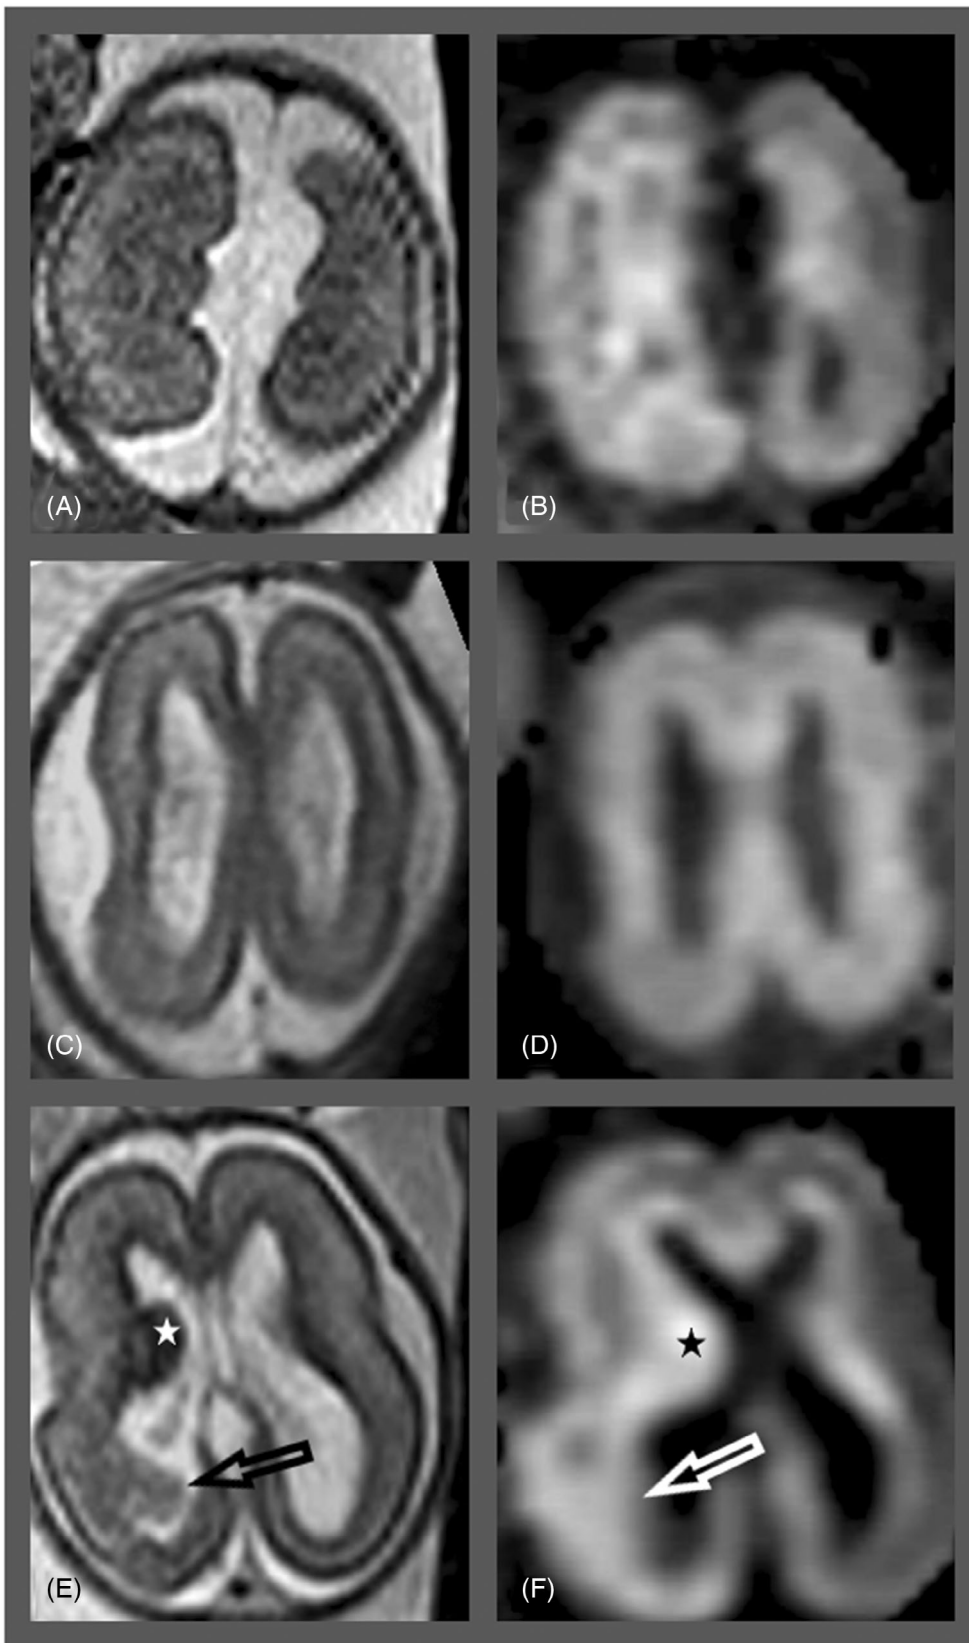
Cortical malformations and loss of cerebral mantle layering. (A, B) in this 21 GW fetus with abnormal medial sulcation (A), DWI shows global loss of layering (B). (C, D) Another 21 GW fetus with abnormal shape of the Sylvian fissures (C) and loss of layering on DWI (D). (E, F) Focal nodular area (arrow, E), probably representing subcortical heterotopia, with corresponding loss of layering on DWI (arrow, F). Notice concurrent ganglionic eminence hypertrophy (star, E, F)
